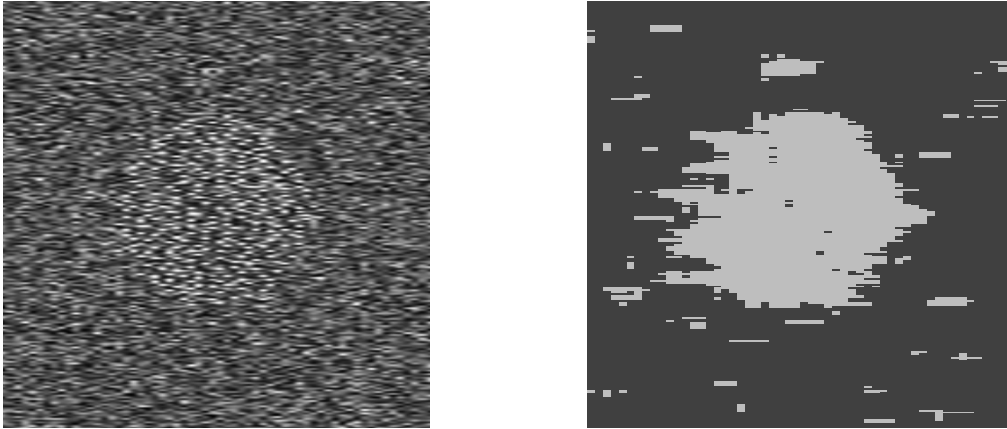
The left image shows a synthetic ultrasonic image with a circular lesion containing calcifications. The right image shows the classification of each pixel using the output of a trained ATFE.
